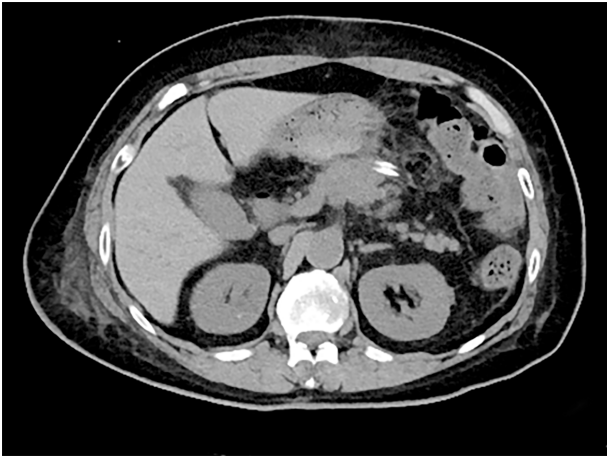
Ten days after surgical resection, computed tomography showed that the pancreatic neck inflammatory myofibroblastic tumor was enucleated, and the tissue of the pancreas remained intact.
